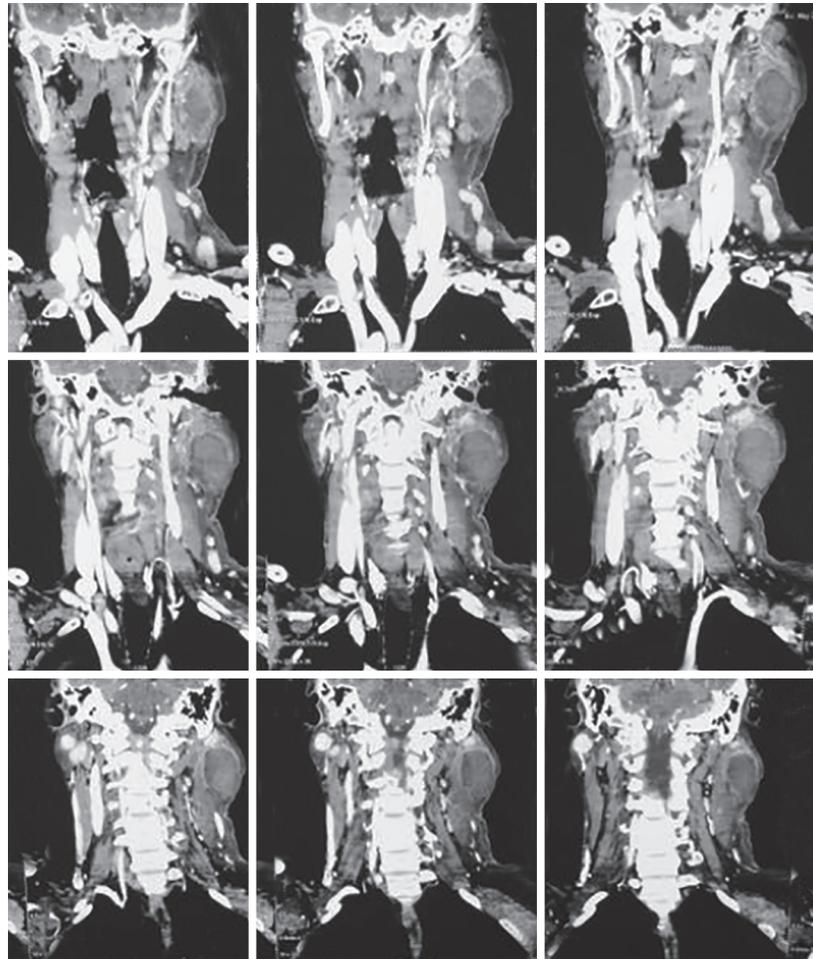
Computed tomography scan showing a well defined lesion involving superficial lobe of left parotid gland with evidence of surrounding hyperaemia
